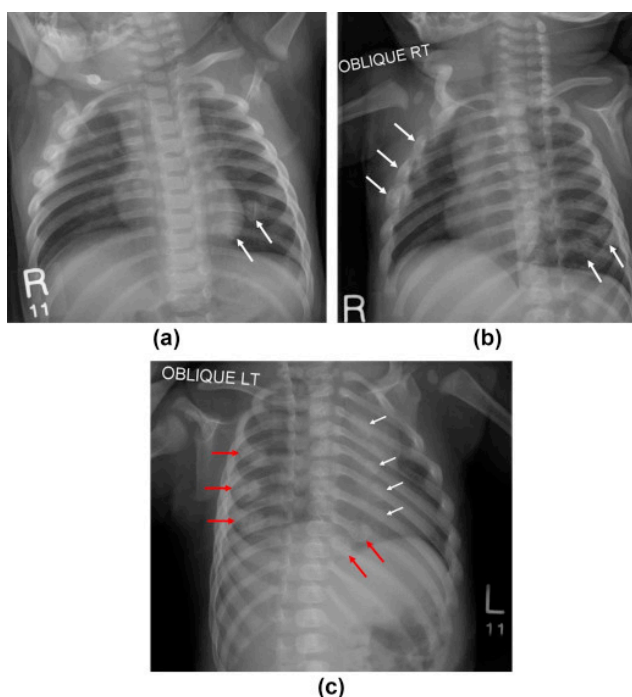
Healing rib fractures in a 3-month-old female infant. (a) AP chest radiograph (arrows), (b) right oblique (arrows) and (c) left oblique (red arrows) show healing fractures of the posterior arcs of the left 8th and 9th ribs and anterior arcs of the right 2nd to 4th ribs. Do not mistake the sternal segments (white arrows) seen in (c) for the healing rib fractures (red arrows).
